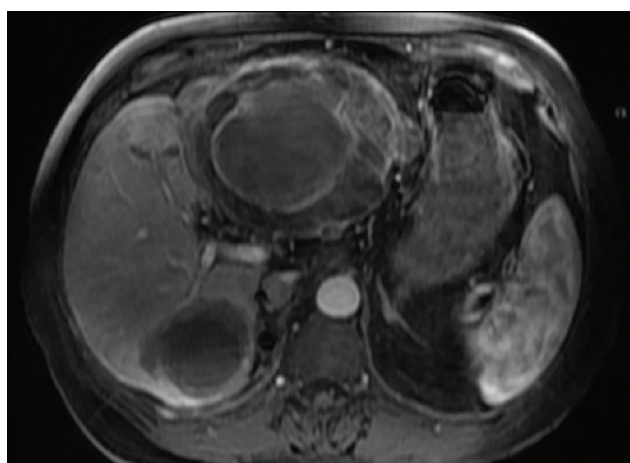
A 4-week postprocedure liver MRI demonstrated 100% complete response.
